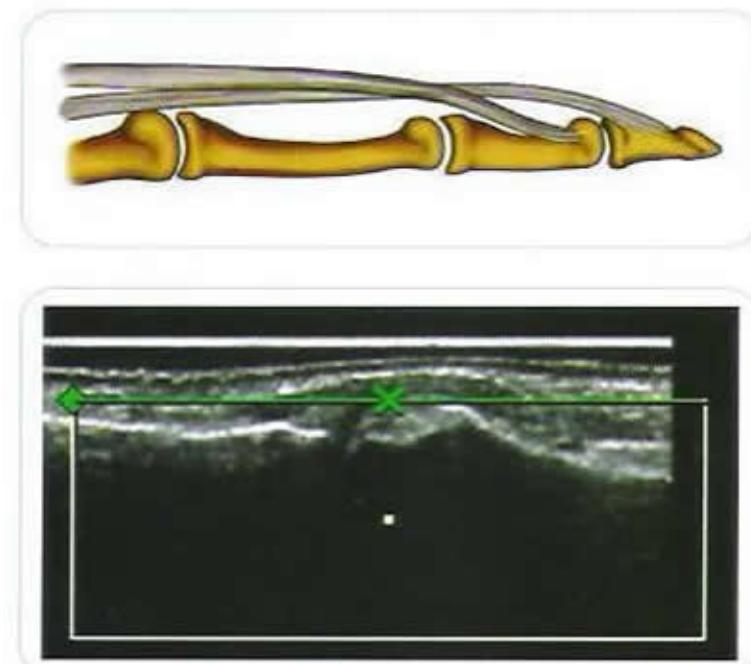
NORMAL DEEP FLEXORTENDON VISUALIZED WITH B-MODE ULTRASOUND
